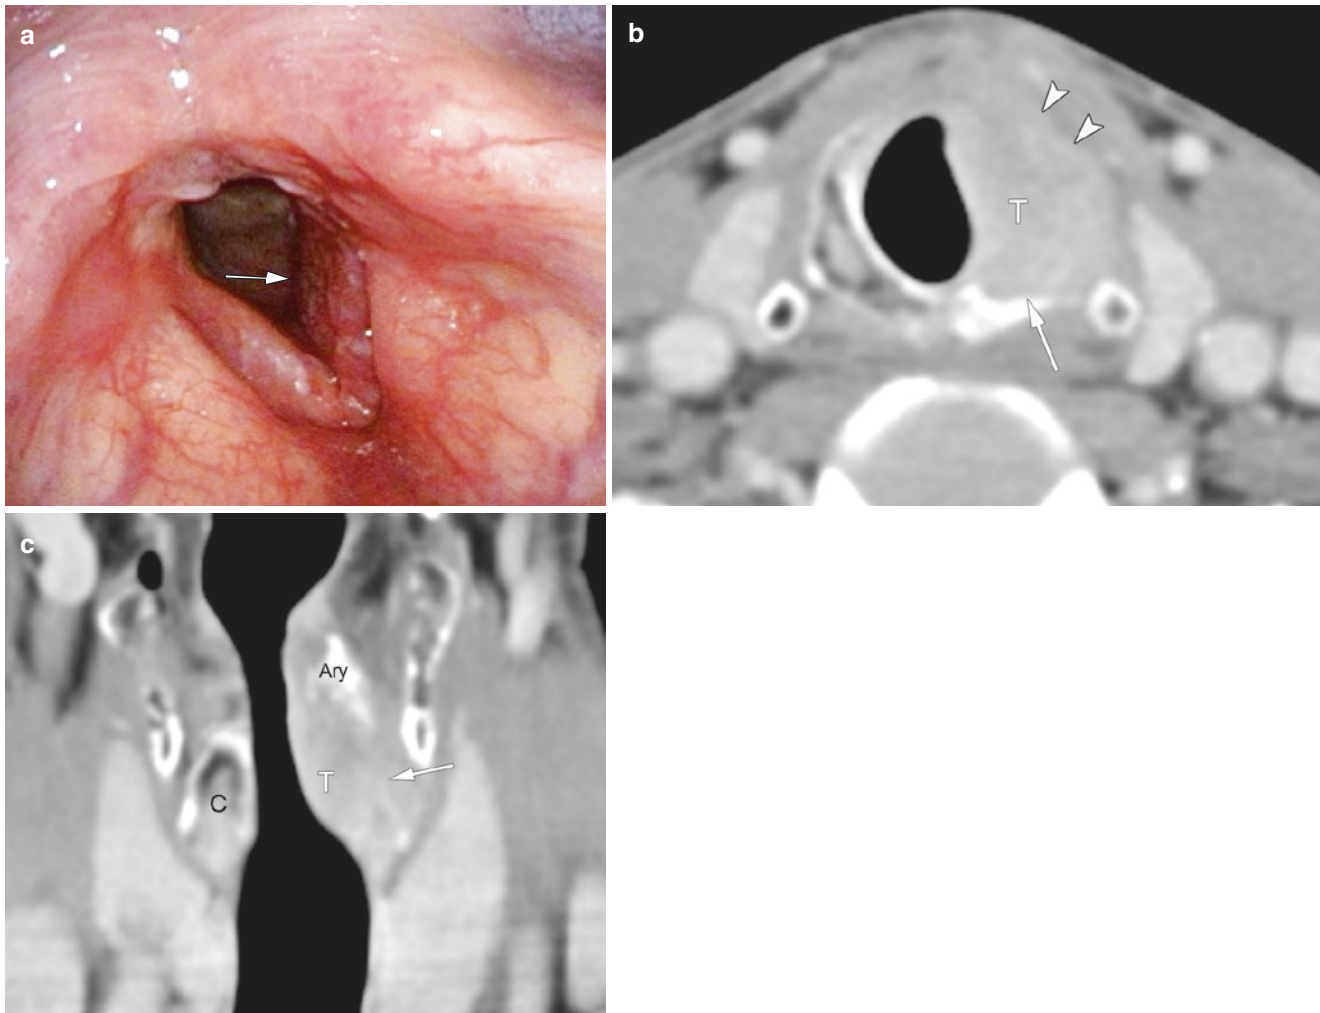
Subglottic carcinoma with cricoid cartilage invasion. Laryngo-fiberscope (a) demonstrates a mass lesion (T) mainly at the subglottis. Axial contrast-enhanced CT image (a) showing the bulky
